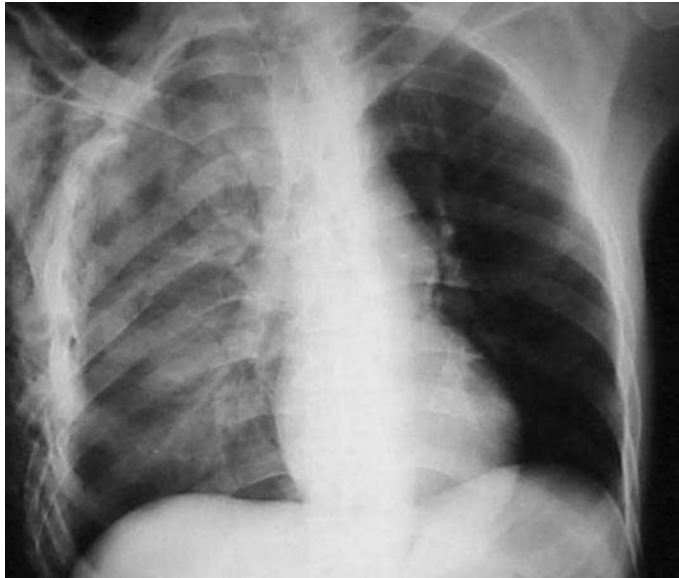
Chest x-ray showing a flail right chest due to multiple rib fractures
